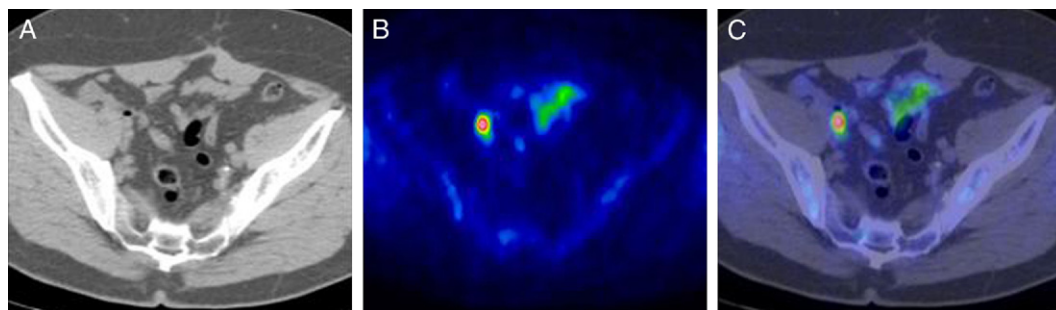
CT (A), PET (B) and fused PET/CT (C) show pathologically increased [¹¹C]choline uptake in patient with right external iliac lymph node. No other pathological uptake sites were noted. Trigger PSA was 2.68 ng/ml. Pelvic lymph nodal area was irradiated with 50 Gy during 5 weeks. PSA was undetectable 3 months after therapy end.
